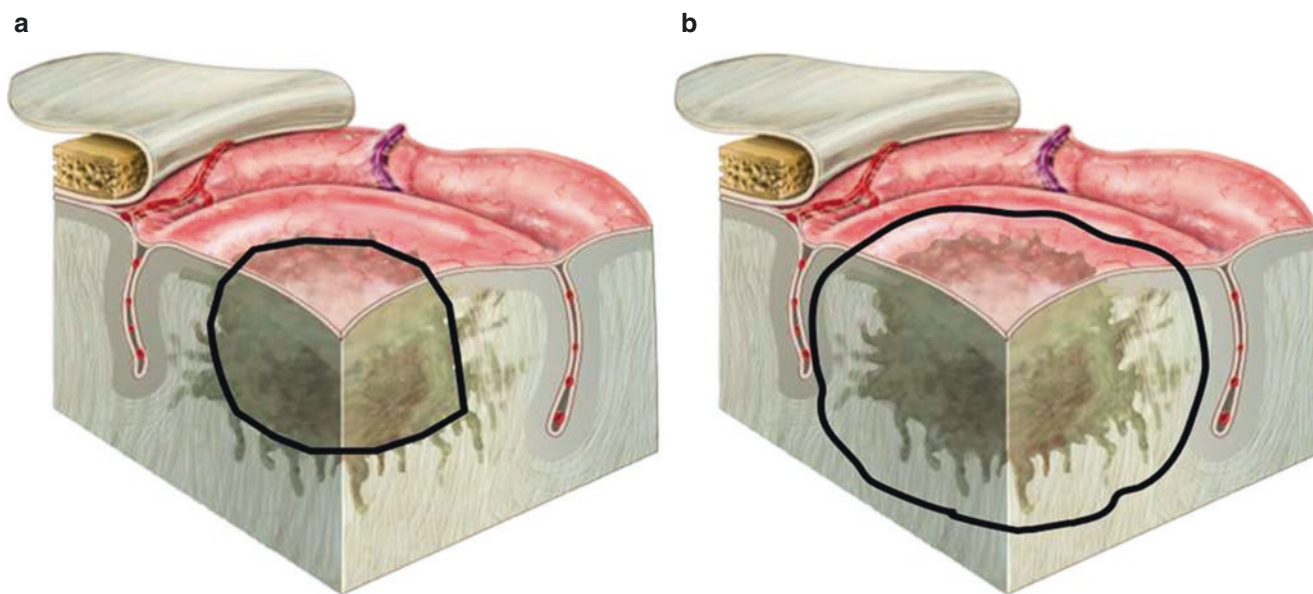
Different surgical approaches to resect an infiltrating intracerebral tumor. (a), A common neurosurgical approach to resect infiltrating intracerebral lesions is to remove only the lesion. This approach might result in a complete surgical resection as defined by complete removal of the contrast-enhancing part in the case of a high-grade glioma and the T2 or FLAIR-defined lesion in the case of low-grade gliomas. In the light of the biological perspective of infiltrating brain tumors, this will not result in a complete resection of the neoplastic tissue. (b), A supramarginal approach addresses the infiltration zone but
